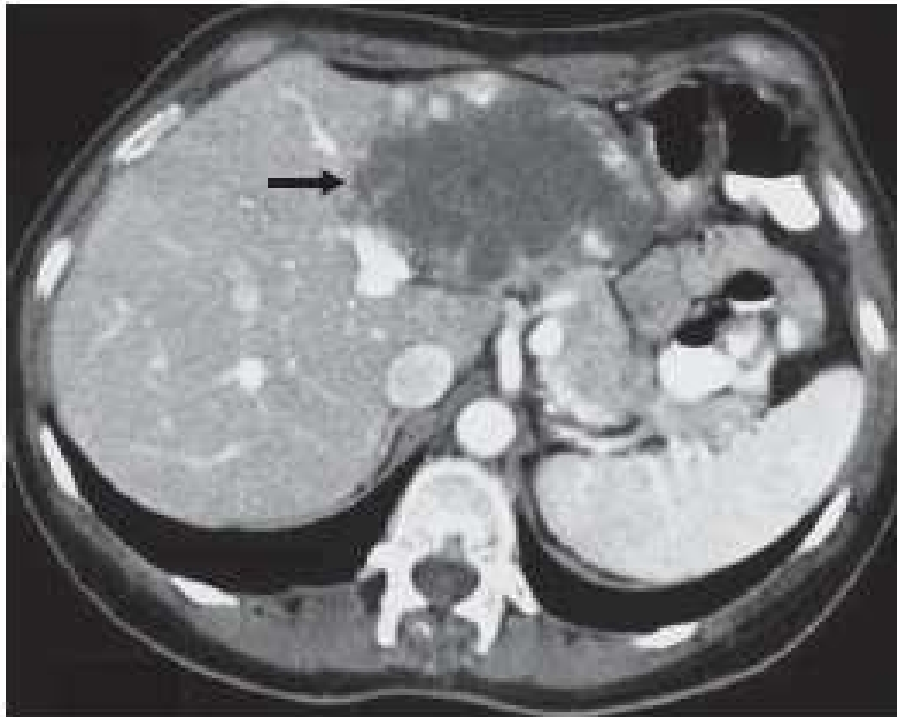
Contrast-enhanced computed tomogram showing a giant heterogeneous mass (arrow) occupying the left segments of the liver.
